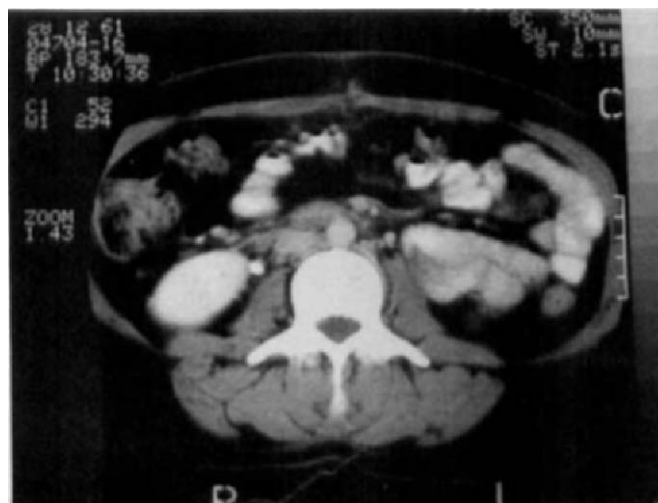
Follow-up abdominal CT scan 3 weeks after surgery. The IVC is free of thrombus.
